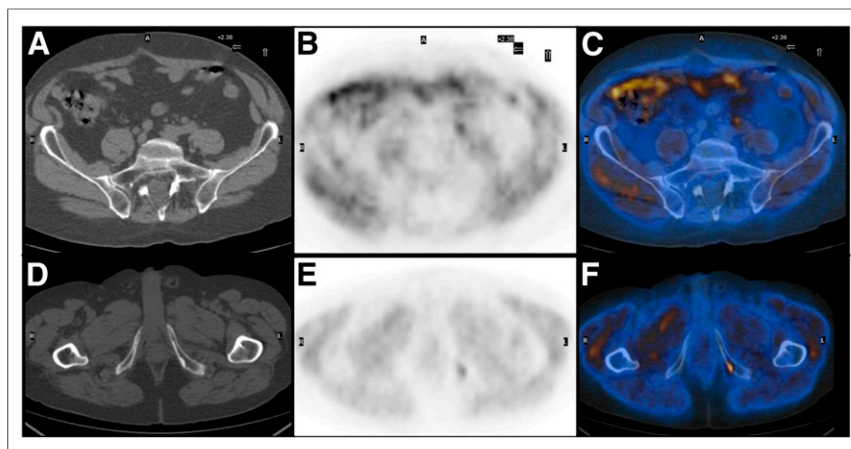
A 76-y-old patient treated with RP for PCa (T2bN0M0; GS = 4 + 3). PSA = 1.95 ng/mL, PSA_{dt} = 4.8 mo, PSA_{vel} = 1.6 ng/mL/y. Patient was scheduled for S-RT. ¹¹C-choline PET/CT performed before S-RT (Fig. 1A) showed pathologic choline uptake in common subcentimetric right iliac LN (CT [A], PET [B], and fusion [C] images) and small solitary bone lesion on left ischium (CT [D], PET [E], and fusion [F] images).
